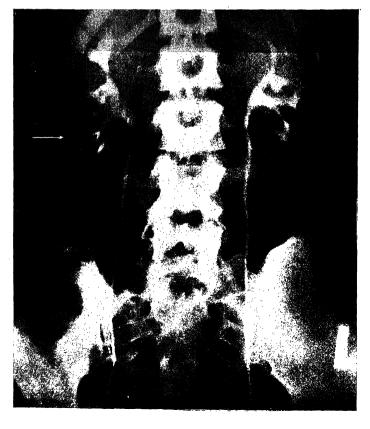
Radiograph of the lumbar vertebræ, after intravenous injection of uroselectan, B. Anterior view. The ureters and their pelves, and the major and minor calyces are well shown. Note the cupping at the extremities of the minor calyces. Note also the relation of the ureter to the transverse processes and that the lateral edge of the left Psoas major muscle can be recognised. The arrow points to the shadow of the right kidney.
